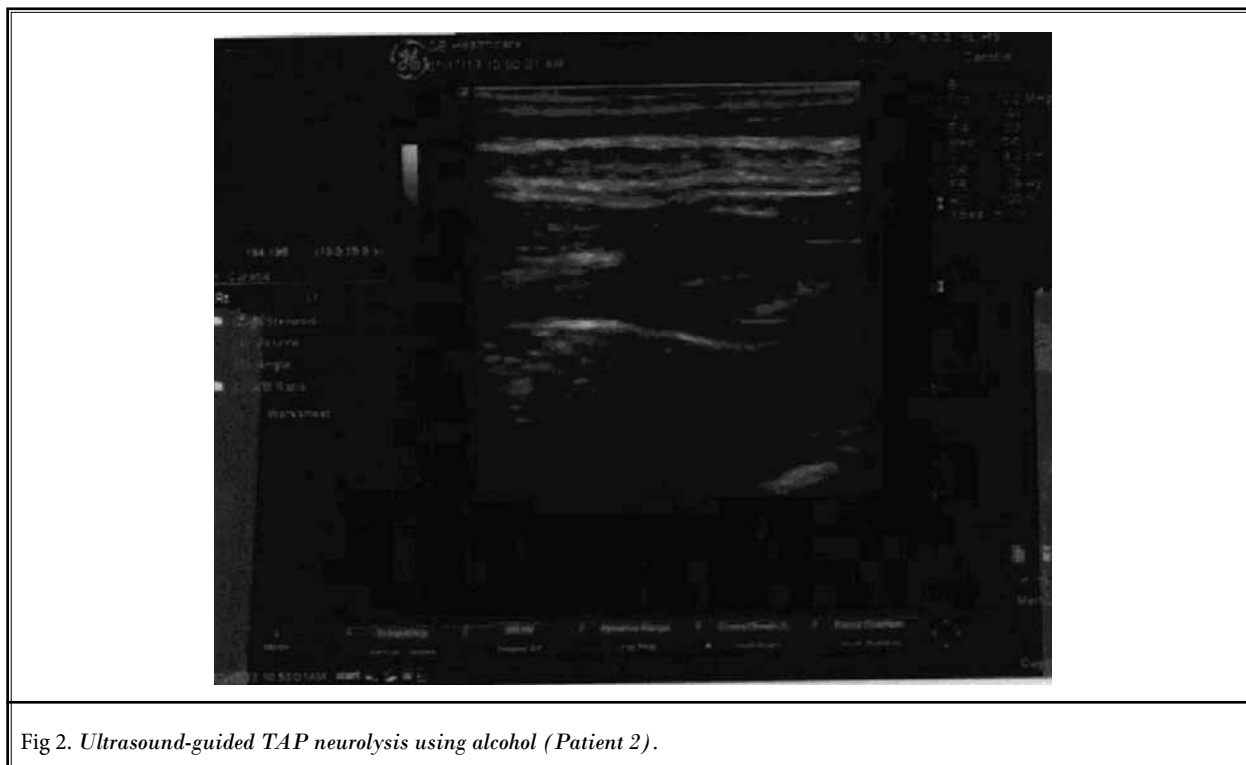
Ultrasound-guided TAP neurolysis using alcohol (Patient 2).*
